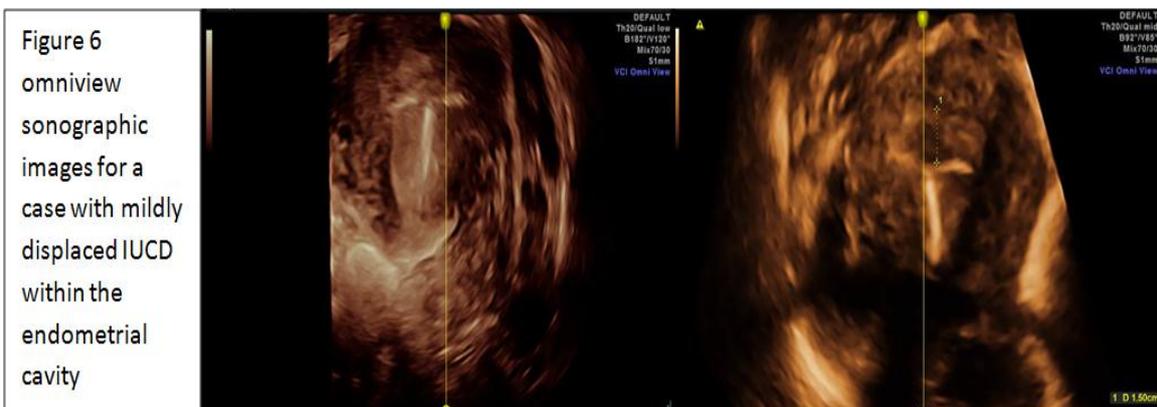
omniview sonographic images for a case with mildly displaced IUCD within the endometrial cavity
